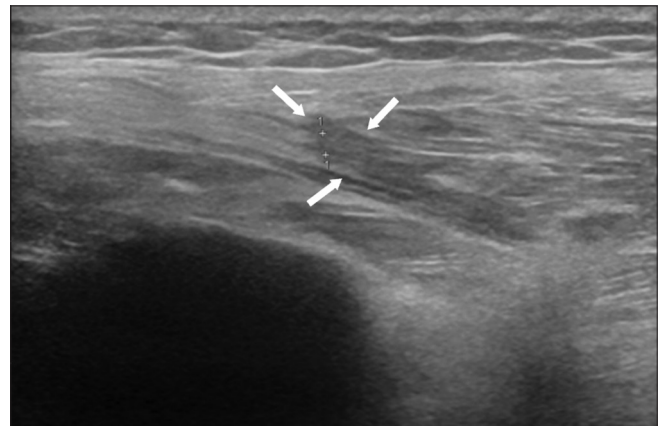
Ultrasound of the right peroneal nerve. The white arrows demonstrate the partial thickness injury of the peroneal nerve at the fibular head.
